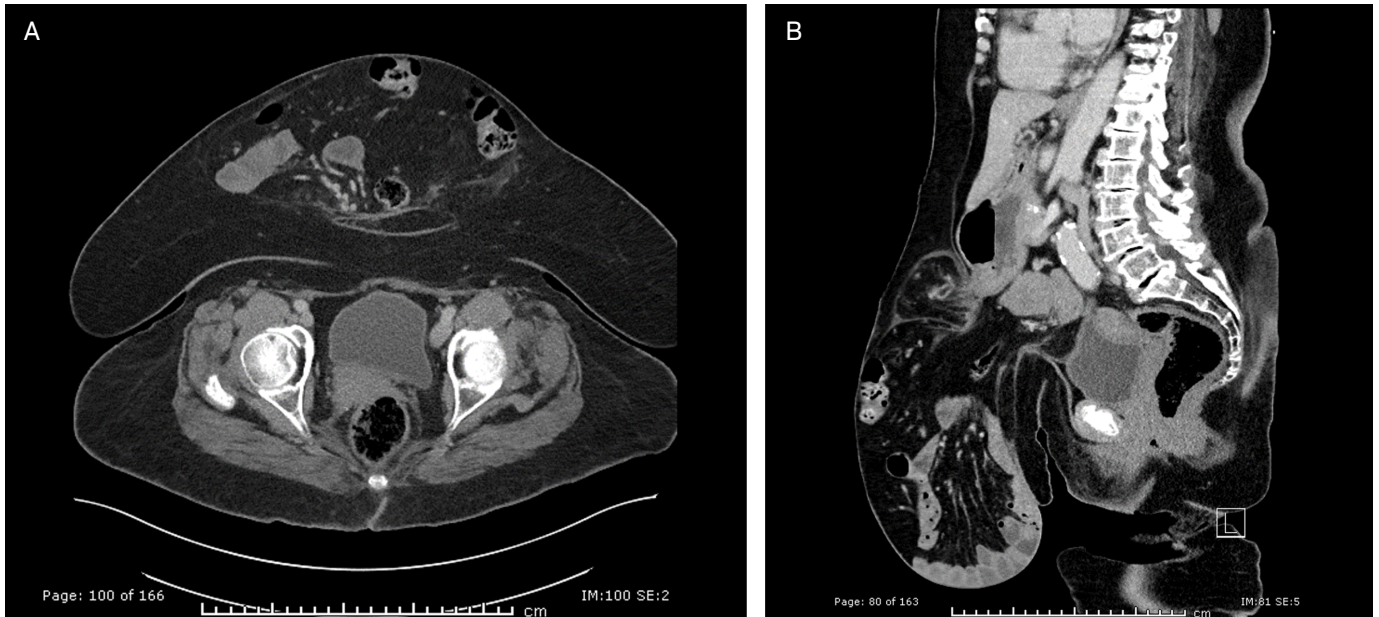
Abdomen and pelvis CT with intravenous contrast obtained 1 month later. (A) Axial slice showing interval herniation of the distal stomach into the sac along with previously seen colon and small bowel. (B) Parasagittal slice demonstrating a significantly distended stomach which narrows as it passes through the hernia neck. The proximal duodenum is also seen in the hernia sac (white arrow). There was no evidence of bowel strangulation. However, the patient had a resultant gastric outlet obstruction at this time, as evidenced by her fluid-distended stomach.
